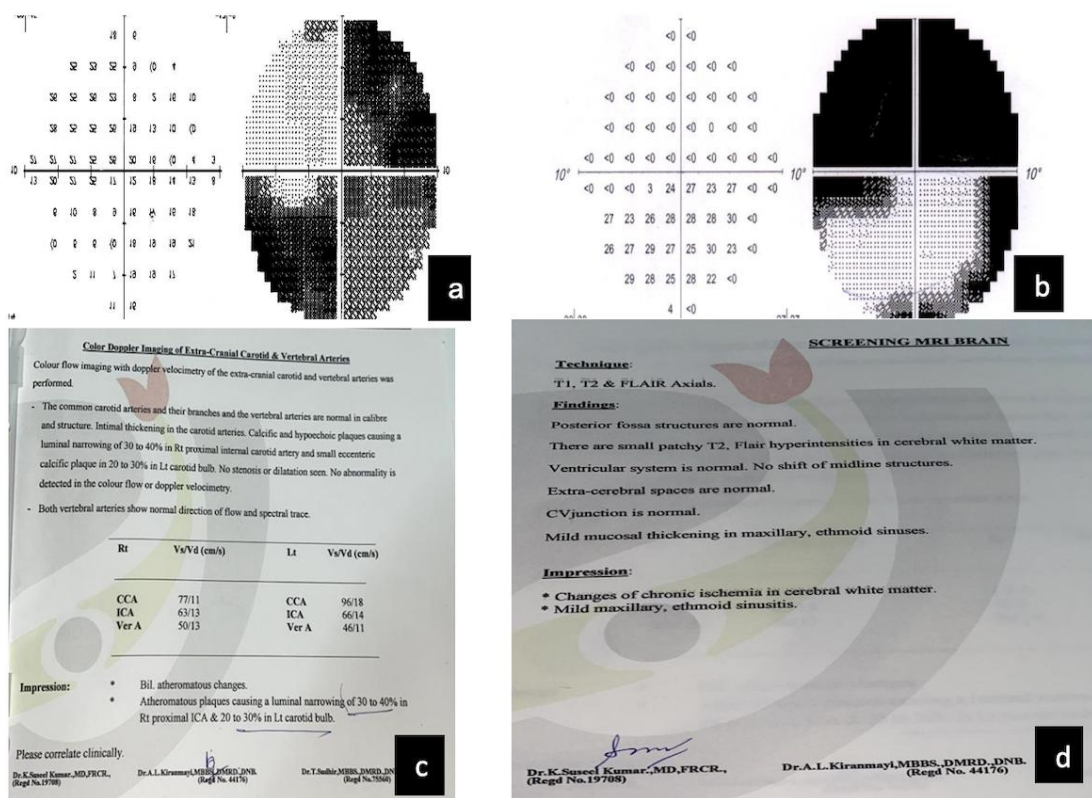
(a) Visual fields on first visit showing biarcuate scotoma without macula split. (b) Visual fields on second visit showing altitudinal scotoma. (c) Doppler report of atheromatous changes in carotids. (d) MRI report showing ischemia in cerebral matter.
